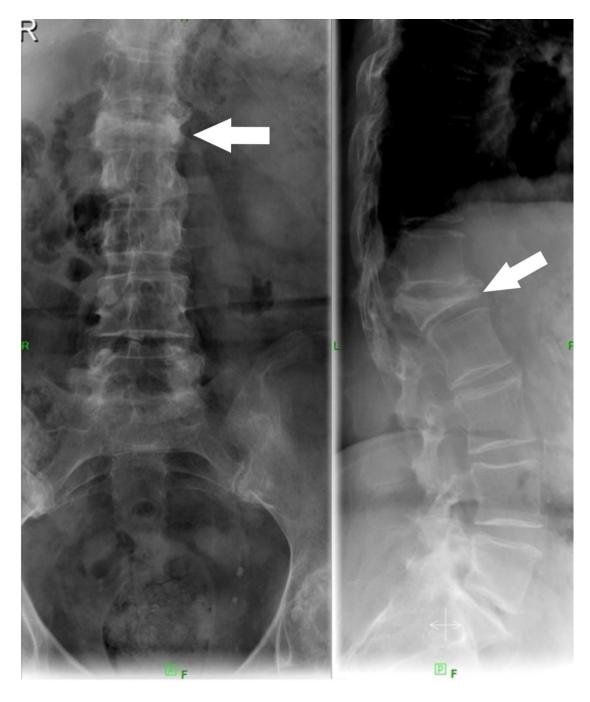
Antero-posterior and lateral projection of the lumbar spine in radiograph.
